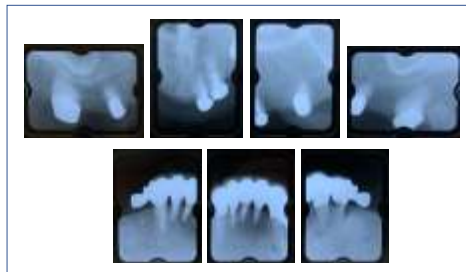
X-ray photographs at 9 years after treatment
